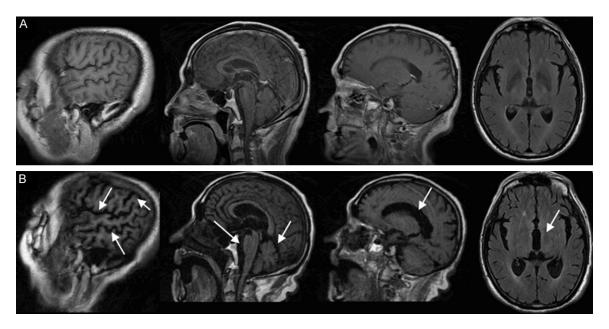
A. Brain MRI FLAIR sequences performed at 12/15/2013. B. Brain MRI FLAIR sequences performed at 4/15/2014. Arrows indicated atrophy in the frontal lobe, temporal lobe, parietal lobe and brain stem, as well as enlargement in the 3^{rd} ventricle and lateral fissure.
